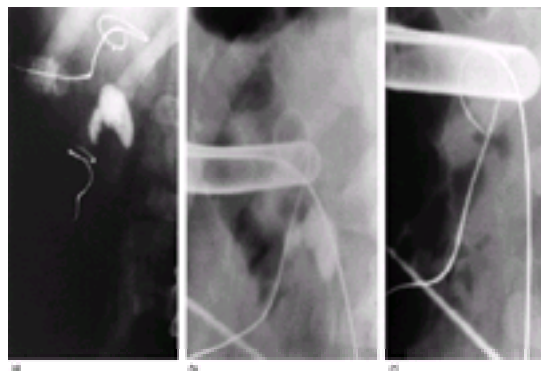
Percutaneous ultrasonic nephrostolithotomy: (a) a large stone in the right kidney; (b) a percutaneous guidewire placed down the ureter and a large percutaneous tube placed into the collecting system of the right kidney; (c) abdominal film of the kidney after ultrasonic desiccation and aspiration of the stone fragments performed through a percutaneous tract; there is no stone remaining.
